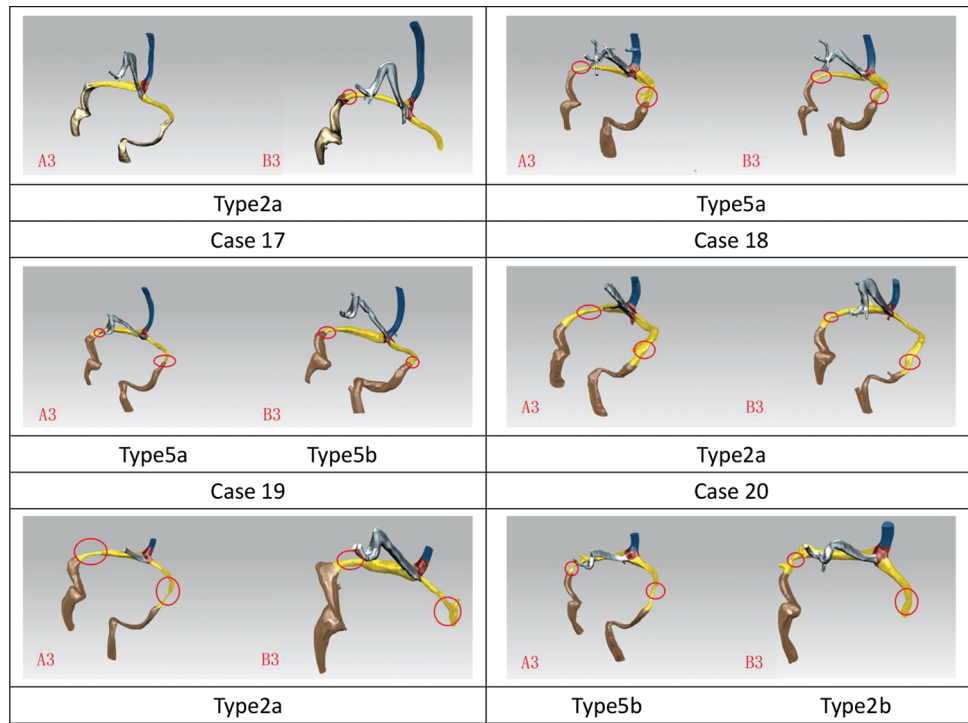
Sinus-wise analysis to compare the number of inlets and outlets between computed tomography (CT)-and magnetic resonance imaging (MRI)-based geometric reconstructions. In general, more inlets were observed at the superior sagittal sinus in CT-based geometric reconstructions, with the exception of Cases 7, 10, 15, 16, 18, and 19. Conversely, additional outlets were detected at the sigmoid sinus (SS) in MRI-based reconstructions for Cases 1, 5, 7, 8, 9, 10, 13, 15, 16, 17, 18, and 19.
